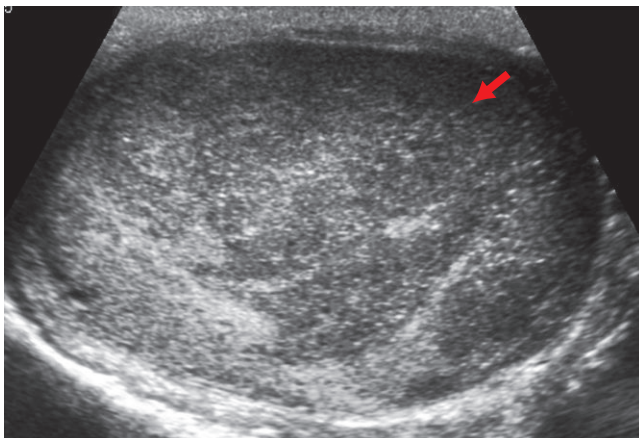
The longitudinal sonographic image of the testis shows a large, solid, hypoechoic mass that nearly replaced the testis (arrow).
